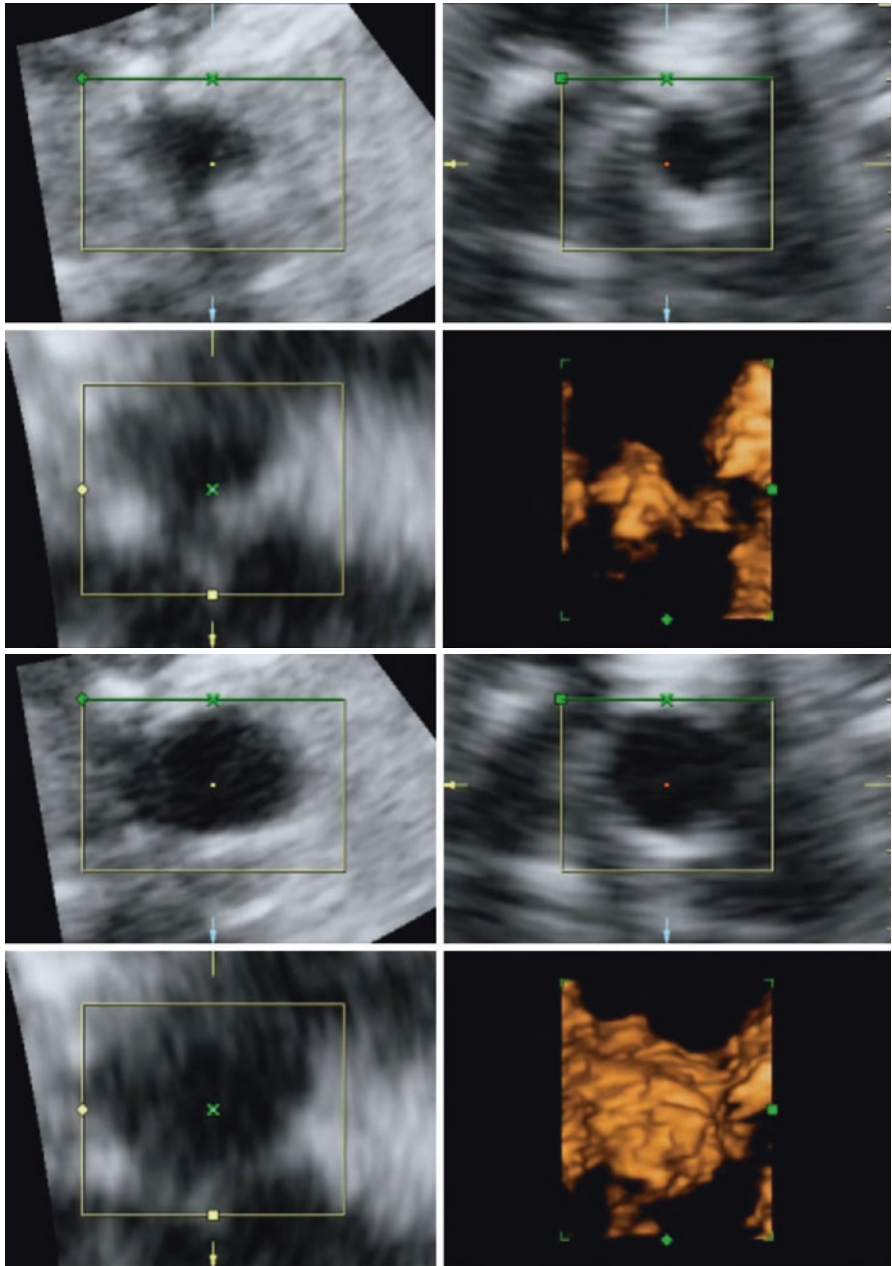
Voiding in third trimester obtained by way of 3-D ultrasound. A bladder volume of appr. 4 mL is reduced to appr. 1 mL during the voiding
